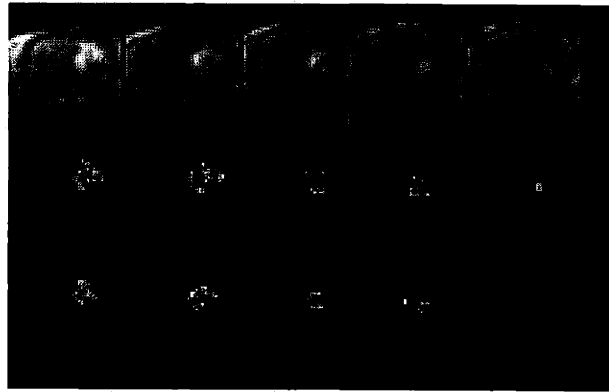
a) Pre-therapy, post-gadolinium T1-weighted MR images. b) Pre-treatment and c) Post-treatment maps of k_{ep} .
